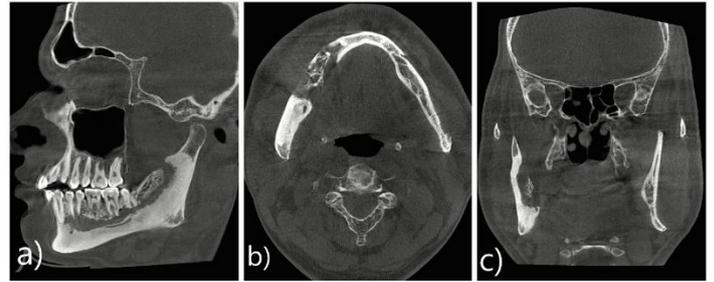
CBCT images a) Moth-eaten radiolucency apical to posterior teeth and hyperdense bone extending till neck of condyle; b) Sequestrum; c) Hyperdense bone, Moth-eaten radiolucency and sequestrum on mandibular right side
